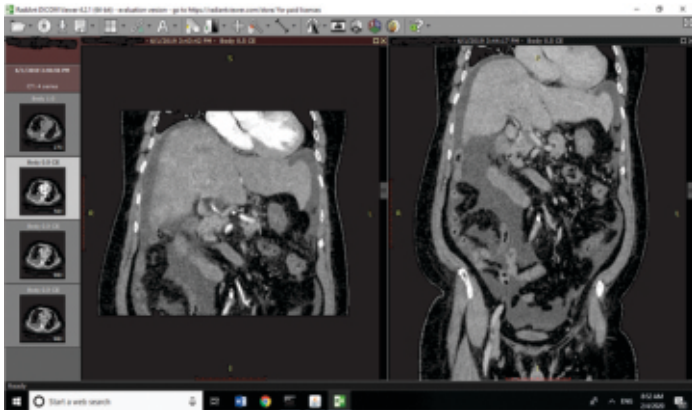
This is the Image from Triphasic CT taken from One of the Patients who was Biopsy proven HCC Positive with AFP of 2016 ng/ml has a Filling Defect in Portal Vein that shows no Enhancement on Arterial Phase (Yellow Arrow) and Hence no Washout on Portovenous Phase. Case of Benign PVT.
